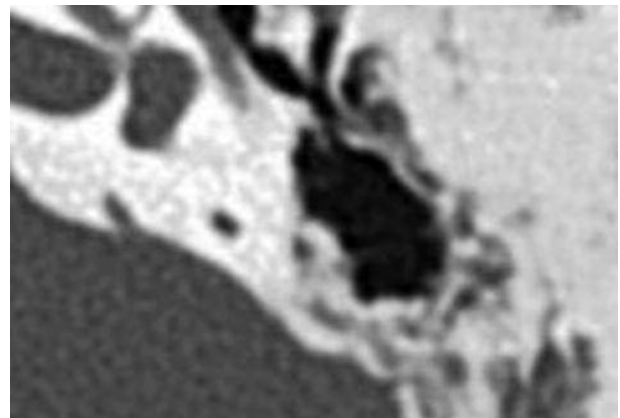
CT scan finding of Stage I (Cholesteatoma not extending beyond the attic)
